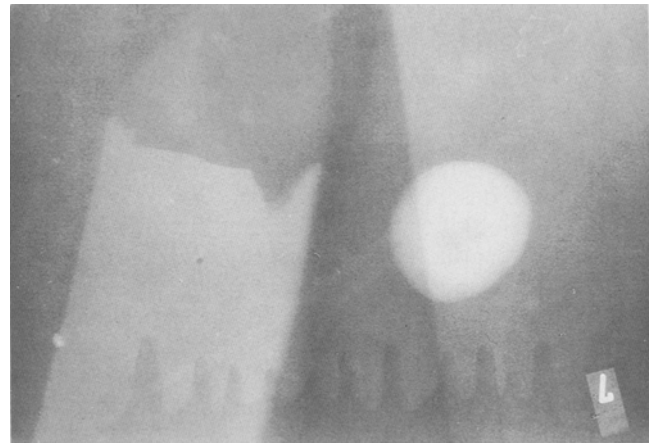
Paint particle by 30 \times direct X-ray magnification. Typical angular and tooth-like structure of the edge. Steelball diameter 1 mm
